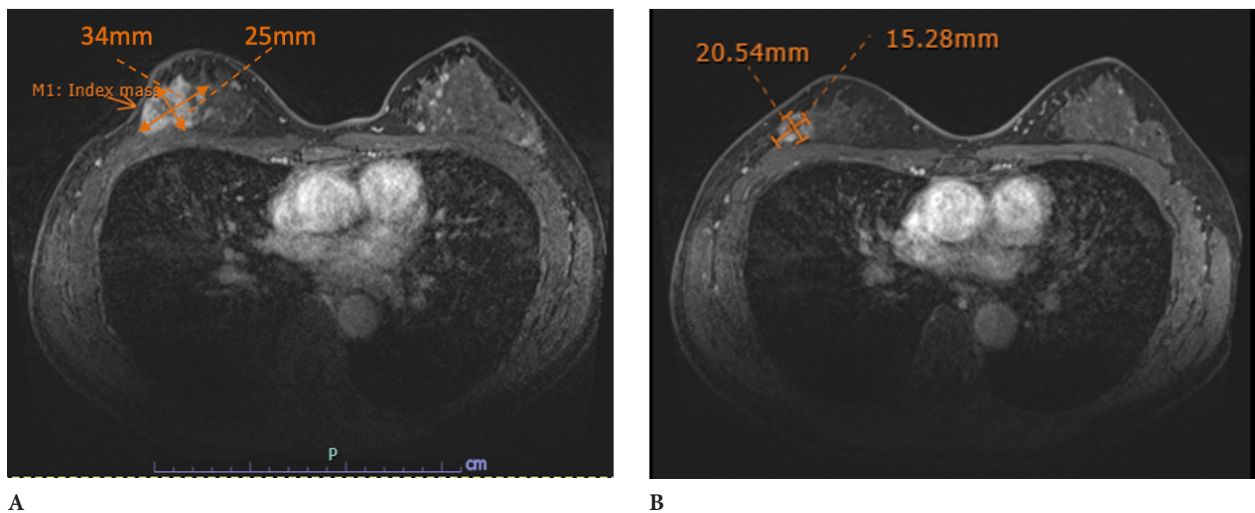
Concentric shrinkage response on MRI. Fig 2A and 2B demonstrate MRI at initial diagnosis and after completion of NAST, respectively.
